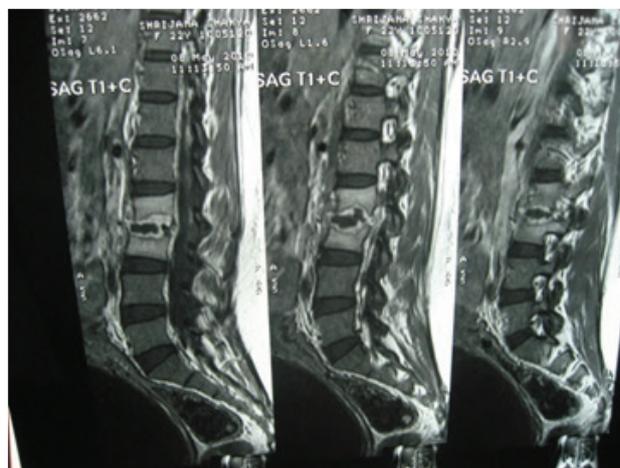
MRI of lumbosacral spine. Lateral View showing destruction and irregularity of end plates at L2, L3 levels.
